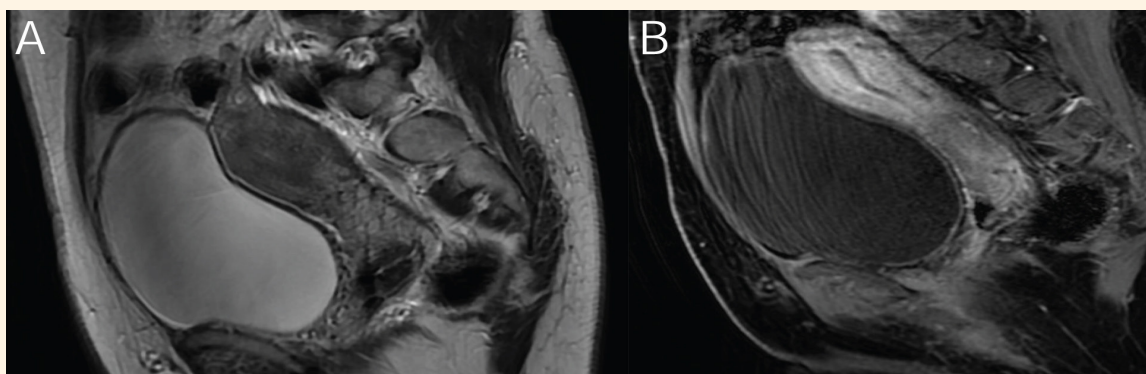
A: Sagittal T2-weighted magnetic resonance imaging (MRI) revealing normal uterus with normal endometrial stripe thickness and signal. B: Sagittal T1-weighted contrast-enhanced fat-suppressed MRI demonstrating normal enhancement with no tumour seen.
